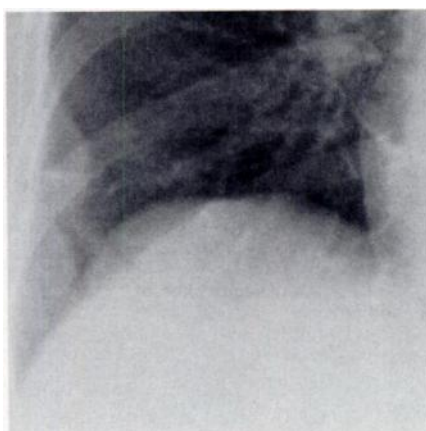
Myelomatous involvement of pleura in a 56-year-old woman. Chest radiograph shows nodular thickening of right lateral pleura, which resolved with treatment. No biopsy was performed.
